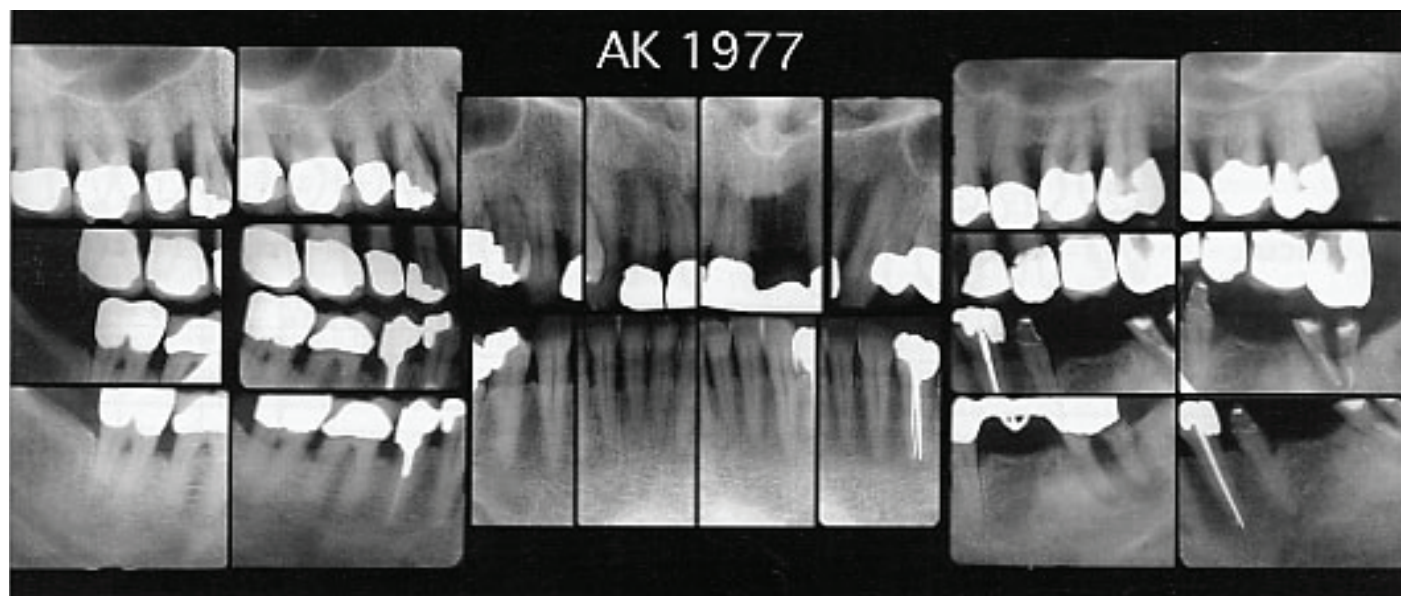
Full-mouth pretreatment X-rays, 1977.
